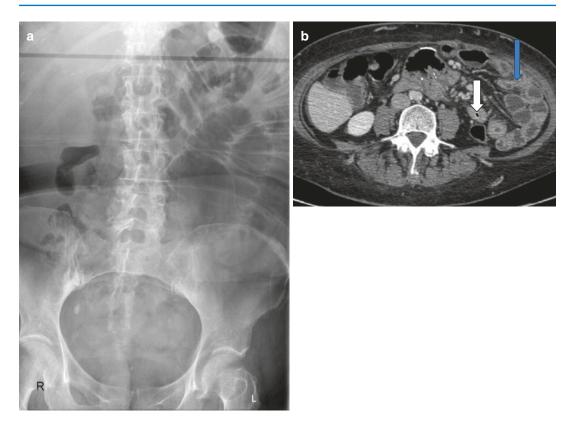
(a) Abdominal X-ray showing proximal small bowel obstruction with dilated jejunal loops in the upper left side of the abdomen. (b) Corresponding CT scan
